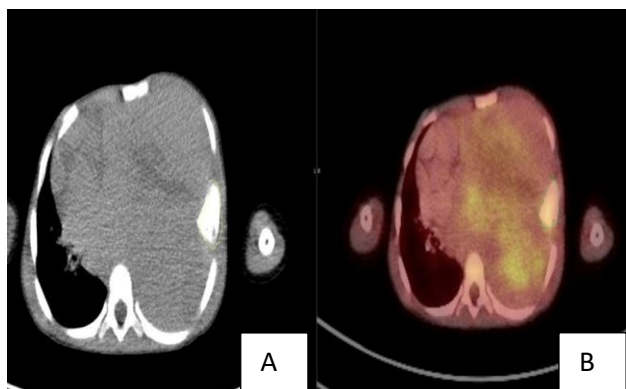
(A and B): PET-CT scan showing a metabolically active mass in the left hemithorax with involvement of the adjacent rib and no evidence of distant metastasis.
